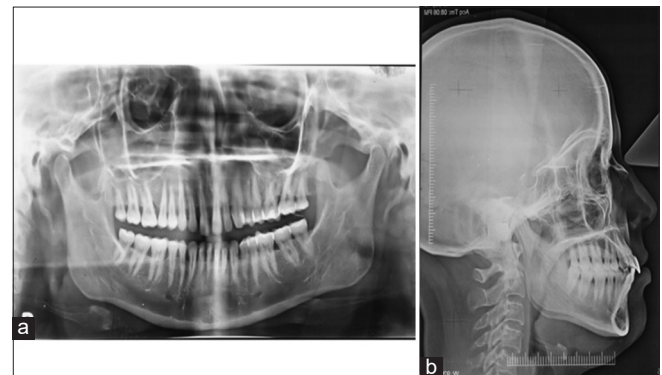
Pre-treatment radiographs (a) OPG and (b) lateral cephalogram
